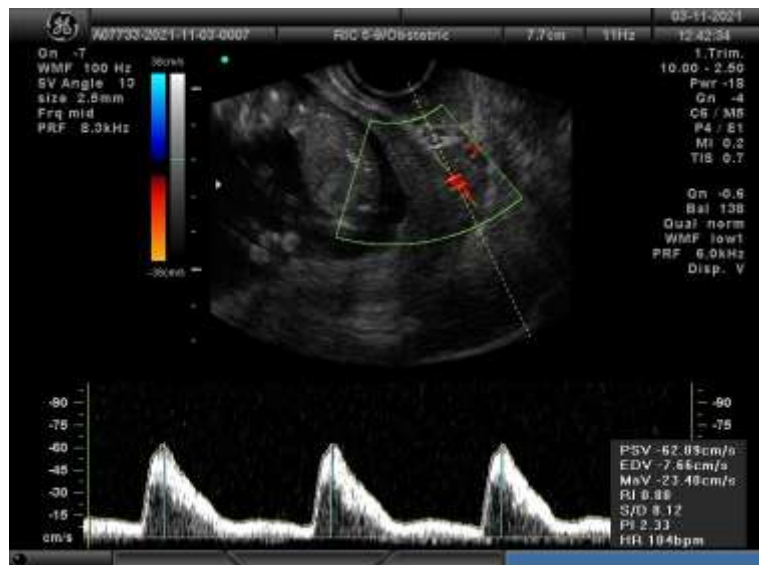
Transabdominal Doppler study of the uterine artery at the level of the internal os in the 1st trimester (screening) Pathological waveform of the uterine artery.
